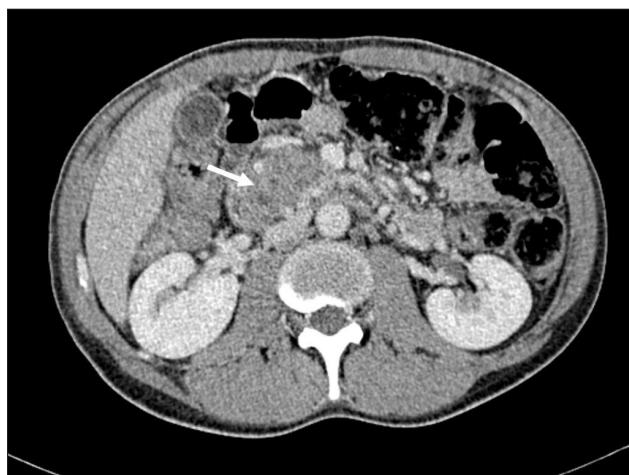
Contrast-enhanced computed tomography of the abdomen (portovenous phase) (pancreas protocol). The arrow marks the hypoattenuating, ill-defined mass in the head of pancreas (slice thickness 1.5 mm).
